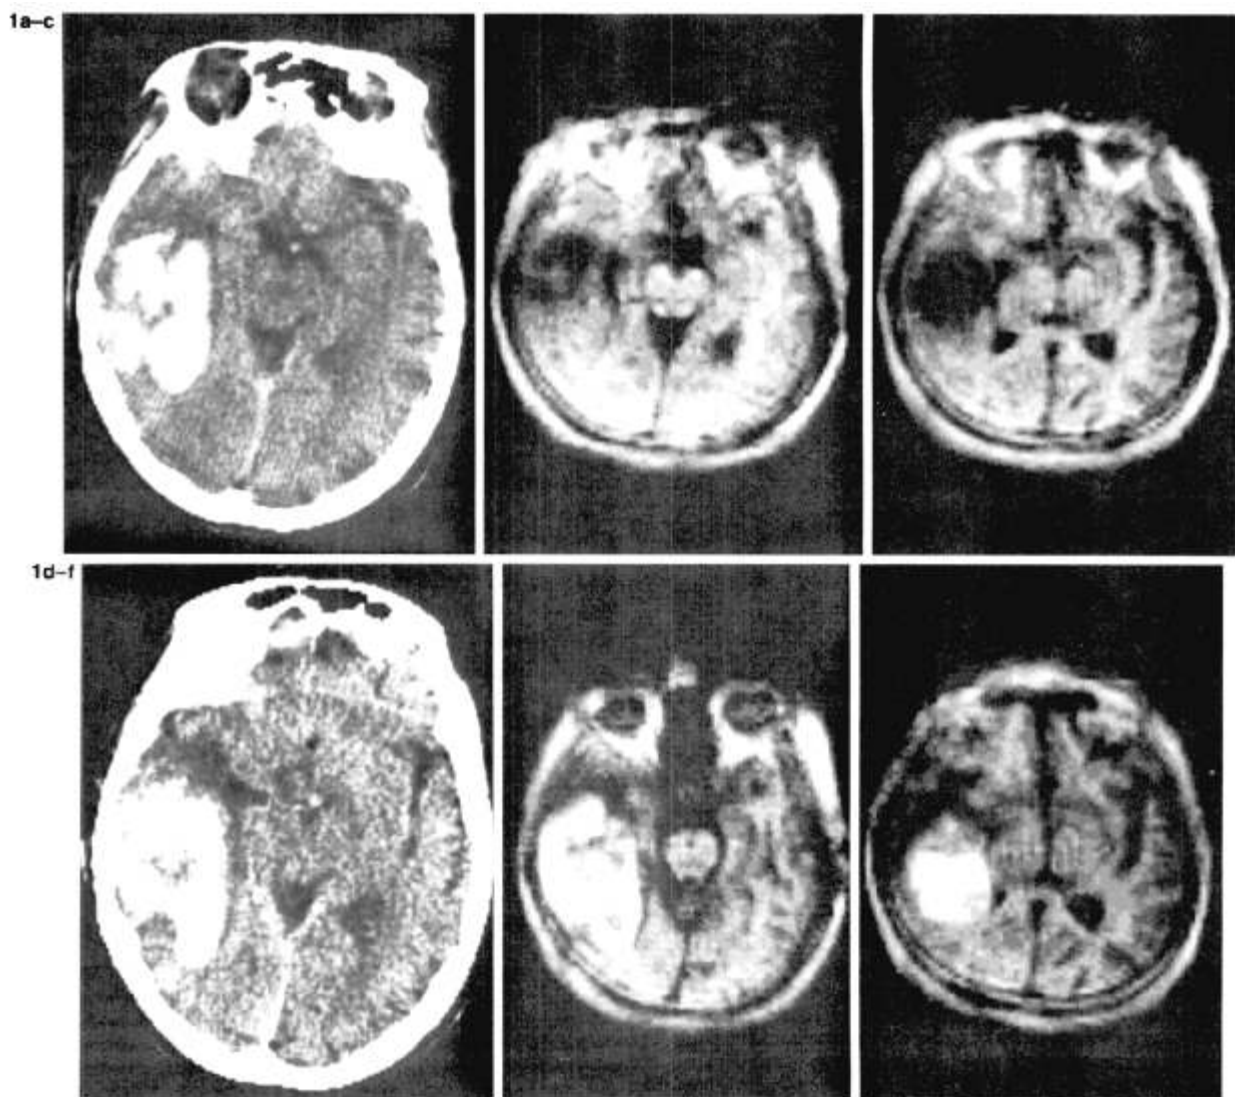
Patient 10. Noncontrast CT (a) and two inversion recovery ($IR_{1,500/400}$) images (b and c) of a 75-year-old woman with an intracerebral hemorrhage 1 day after the onset of symptoms. Repeat CT (d) and IR (e and f) at 10 days indicate a considerable change in visualization of the hematoma in the resolving phase.
